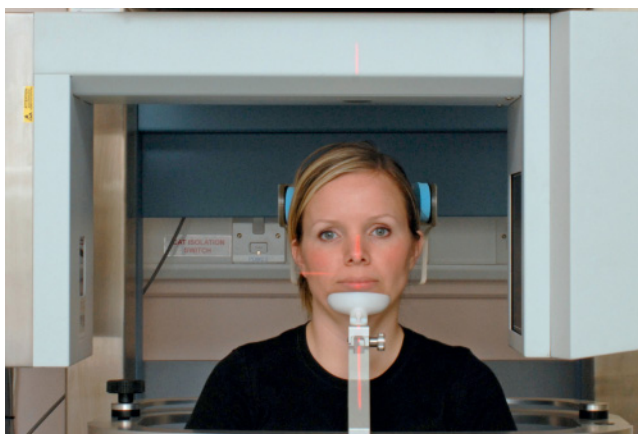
Correct positioning of the patient for cone beam computed tomography scanning is attained using a series of laser beam markers and stabilization aids such as a chin cup. (With thanks to Nicola O’Kelly.)
